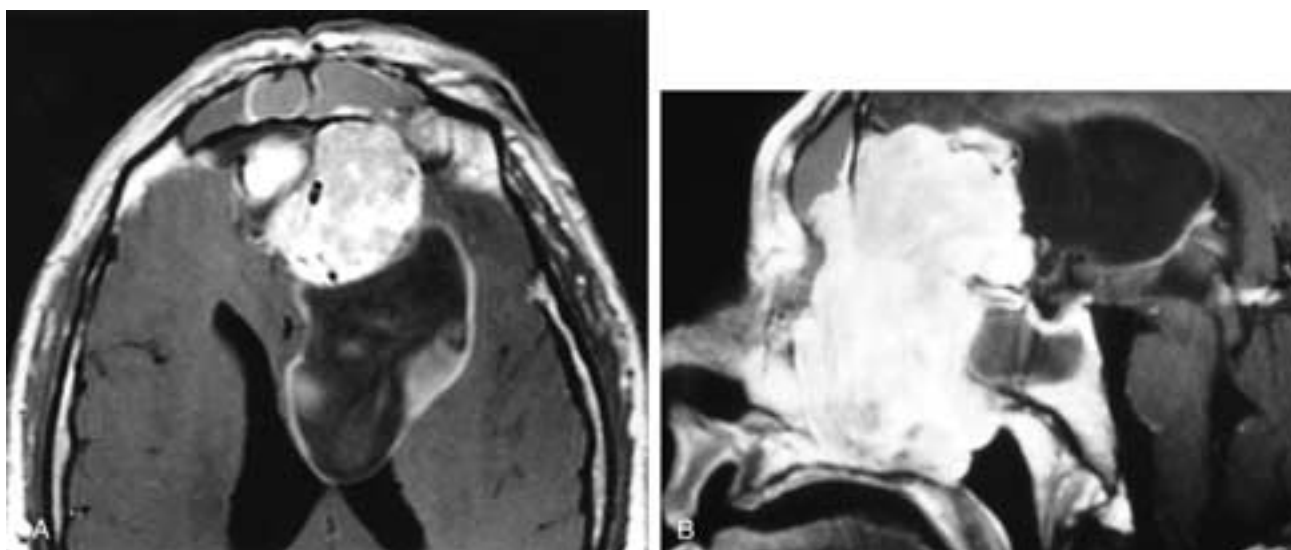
Axial (A) and sagittal (B) T1-weighted, fat-suppressed, contrast-enhanced MR images show a large, enhancing sinonasal mass that obstructs the frontal and sphenoid sinuses and extends intracranially. There is a large cyst at the intracranial margin of the tumor. This patient had an olfactory neuroblastoma.
